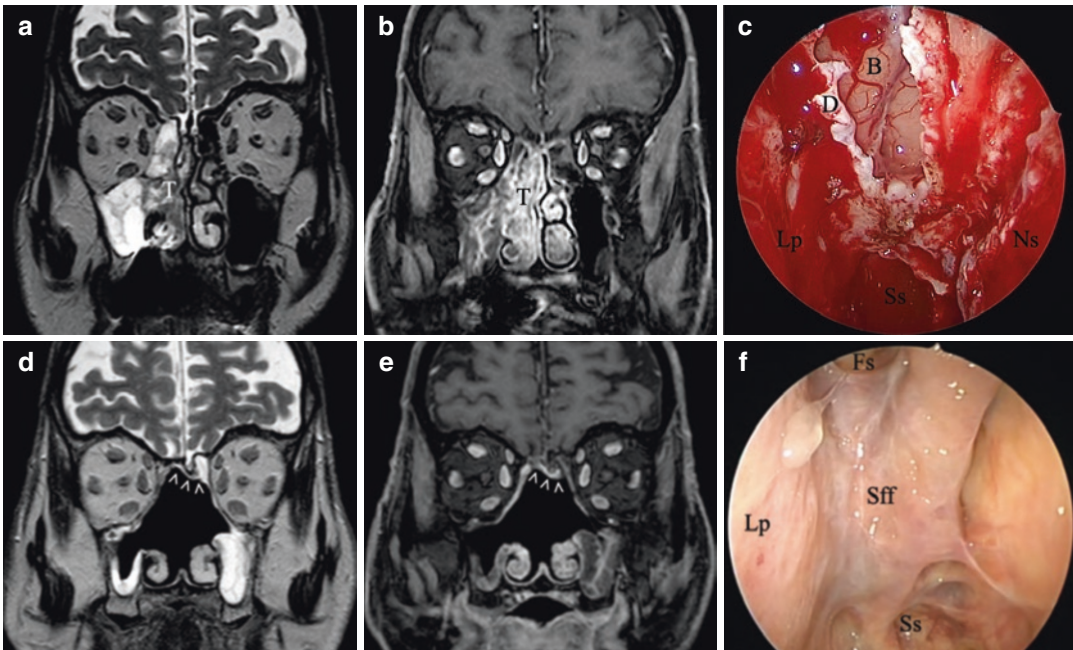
A 78-year-old male, former woodworker, affected by right sinonasal intestinal-type adenocarcinoma G1 (T3N0M0). Preoperative MRI scans in coronal views ((a) T2W; (b) T1W with contrast). Right endoscopic resection with transnasal craniectomy (ERTC) and skull base reconstruction with fascia lata and septal flip flap was performed ((c) right nasal fossa intraoperative
